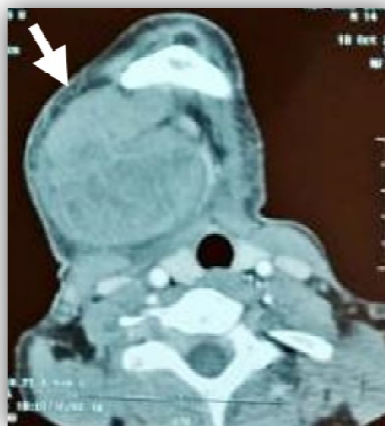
CT scan results showing tumor-like right latero-cervical formation
